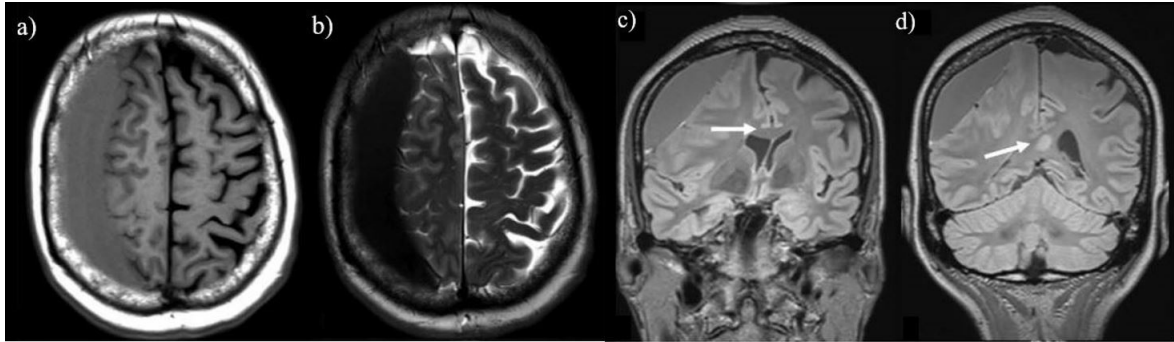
Axial T1w (a) and T2w (b) imaging demonstrates a large acute subdural haematoma along the right cerebral convexity. Reformatted coronal T2w FLAIR imaging shows leftward subfalcine herniation (c) and a focus of axonal injury involving the splenium of the corpus callosum (white arrow) (d). Source: Kazam et al.[33].
